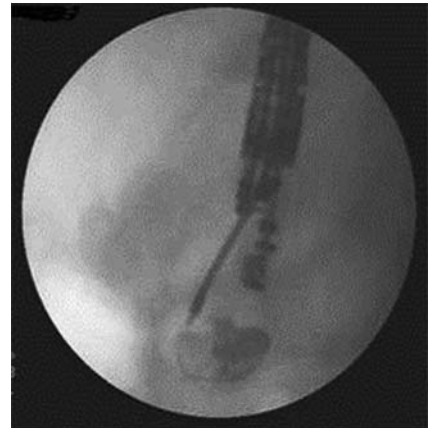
Radiographic image showing the main pancreatic duct punctured by the 19-gauge needle.
